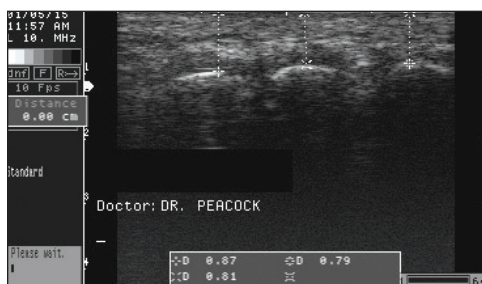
Ultrasound, five months post-op.
